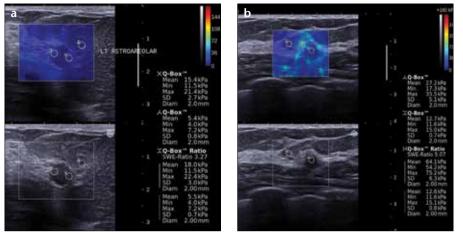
a, b. Shear wave elastographic examination of two BI-RADS IV lesions that proved to be grade 1 invasive ductal carcinoma. Upon shear wave elastographic ultrasound examination, both lesions were blue (a). Mean elasticity value of the lesion, 18 kPa; maximum elasticity value of the lesion, 22.4 kPa; minimum elasticity value of the lesion, 11.5 kPa; mean elasticity value of fatty tissue, 5.5 kPa; mass/fat ratio, 3.27; ROI diameter, 2 mm. This was the only false-negative case encountered. Stiff areas were found only in the periphery of the lesion and are coded green (b). Mean elasticity value of the lesion, 64.1 kPa; maximum elasticity value of the lesion, 75.2 kPa; minimum elasticity value of the lesion, 54.2 kPa; mean elasticity value of fatty tissue, 12.6 kPa; mass/fat ratio, 5.07; ROI diameter, 2 mm.
